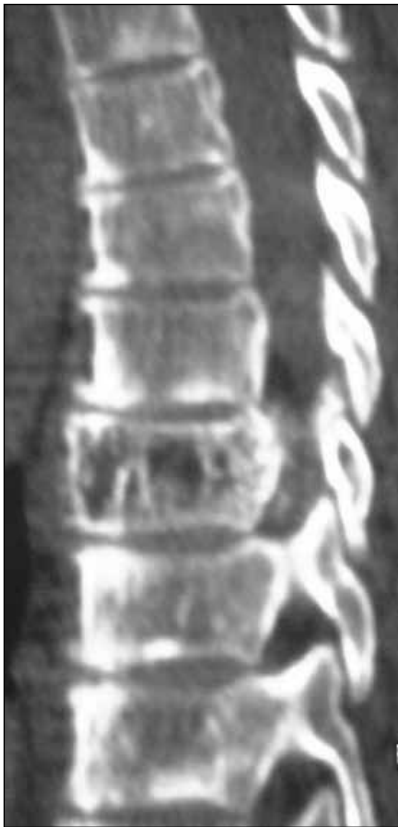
Computed tomography of thoracic spine showing T8 vertebral hemangioma.
